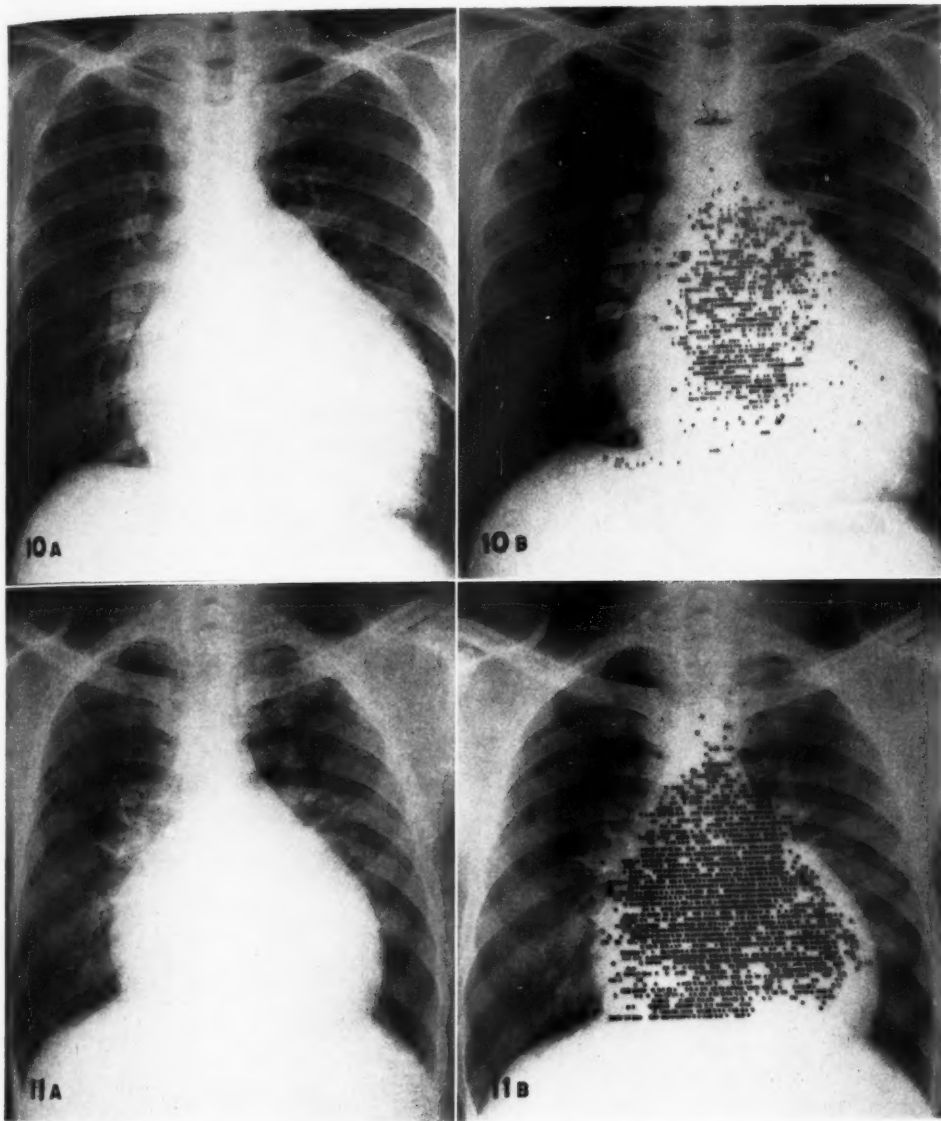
A. Postero-anterior roentgenogram of chest of patient with an enlarged cardiac silhouette. B. Superimposition of scan of cardiac blood pool on roentgenogram indicates marked discrepancy between cardiac silhouette and blood pool, typical of pericardial effusion.
